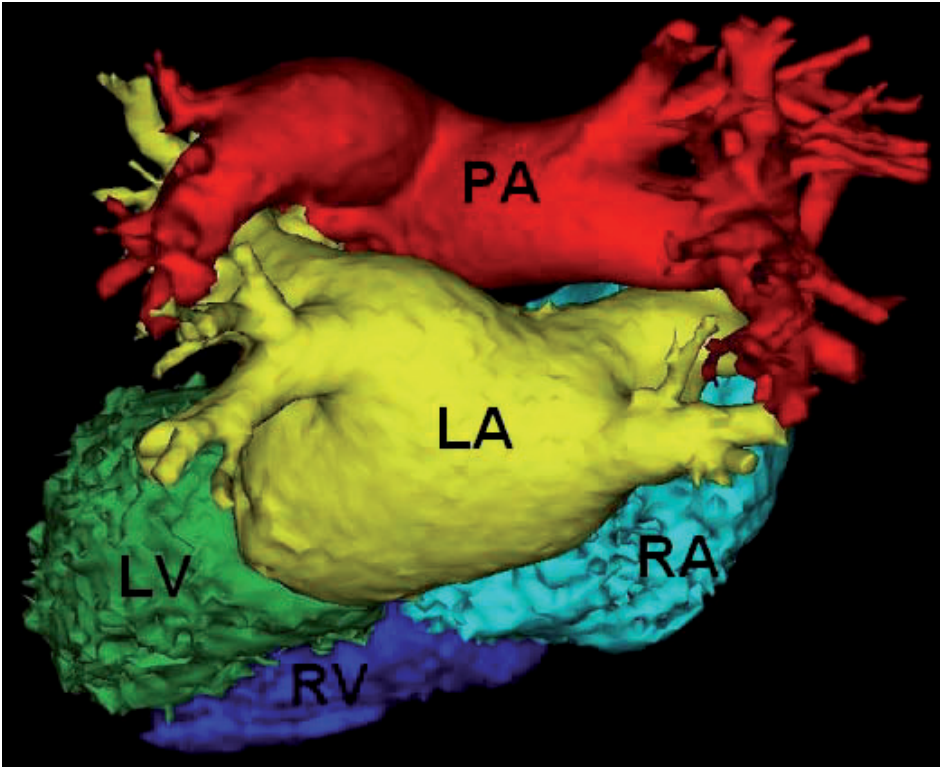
Multislice computed tomography image after segmentation using the CartoMerge™ Image Integration Module. Segmentation included: creation of a 3D volume, placement of anatomical markers on different structures and implementation of an algorithm that creates the different structures of interest (see text). LA = left atrium; LV = left ventricle; PA = pulmonary arteries; RA = right atrium; RV = right ventricle.
